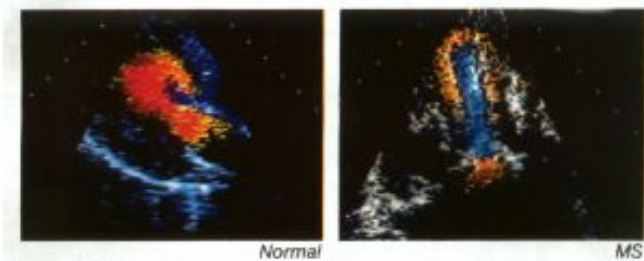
Color Doppler images were captured by Aloka SSD-880CW color Doppler system. It is the world’s first system to display blood flow imaging in color and real time. (Permission from Dr. Joseph S.K. Woo)
